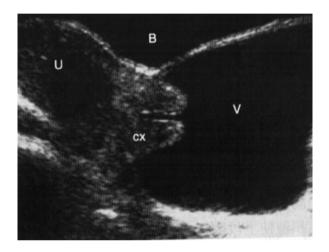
Ultrasonography of retention of blood in the upper vagina
